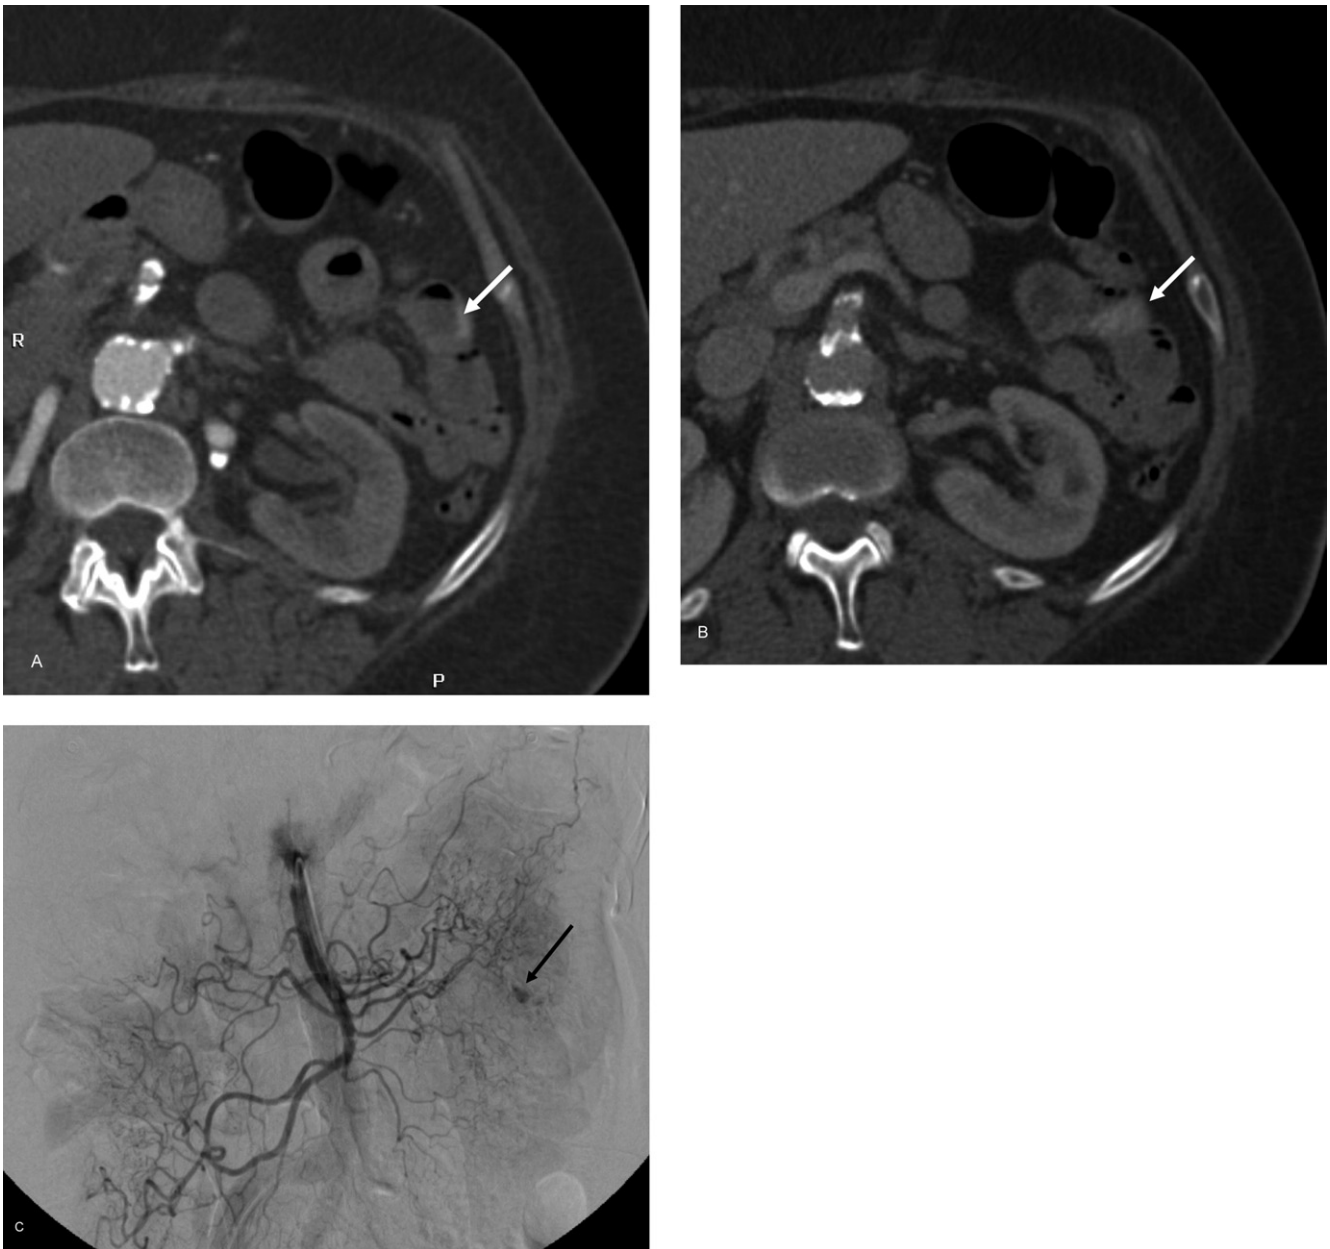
A 70-year-old woman with atrial fibrillation on Coumadin therapy admitted to the emergency department. Physical examination revealed red blood per rectum. Mesenteric CTA was obtained. (A) Arterial phase image shows hyperdense material (*white arrow*) within the jejunum lumen. (B) Late venous phase axial CT image demonstrates increased amount of hyperdense material, which was predictive of active contrast extravasation into the jejunum lumen. (C) Selective SMA catheterization confirms the evidence of active gastrointestinal hemorrhage in the proximal jejunum (*black arrow*).
